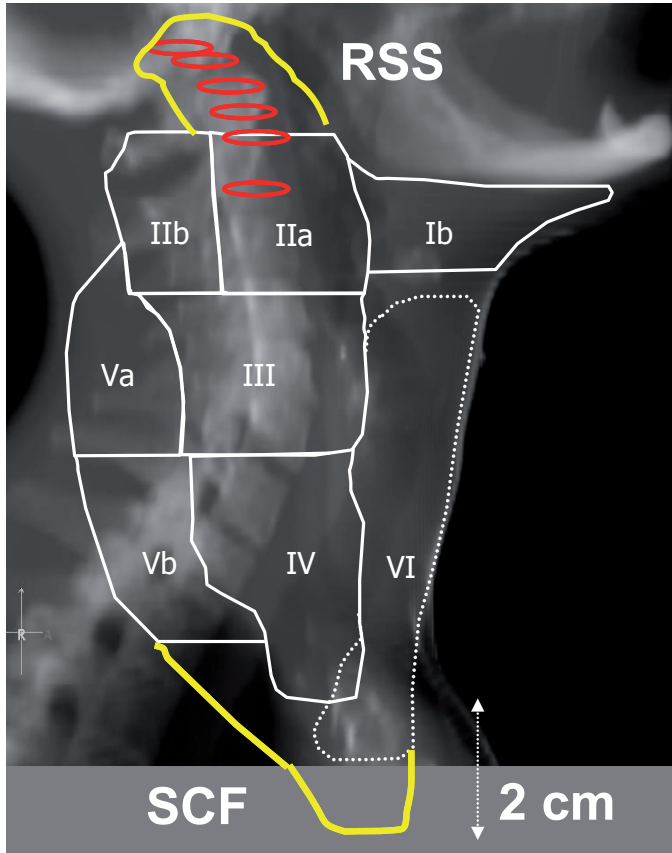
Digital Reconstructive Radiograph with levels Ib-VI, including delineation of the Retro-Styloid Space (RSS) and Subclavicular Fossa (SCF).
